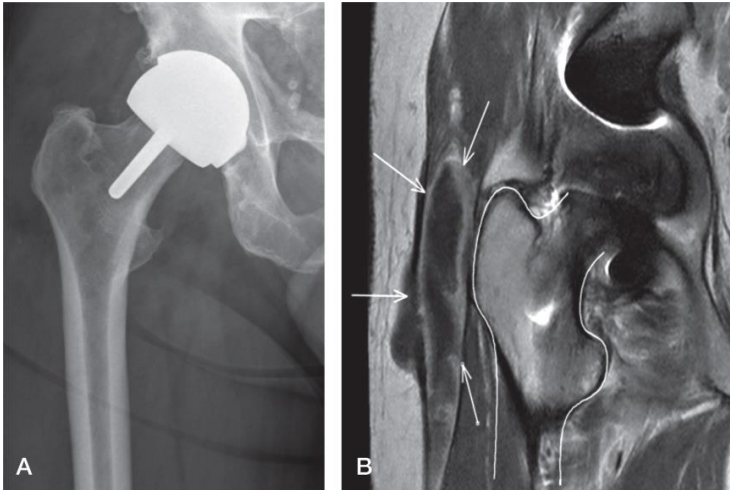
A radiograph (panel A) and an MRI image (panel B) of a BHR hip with a pseudotumor.
